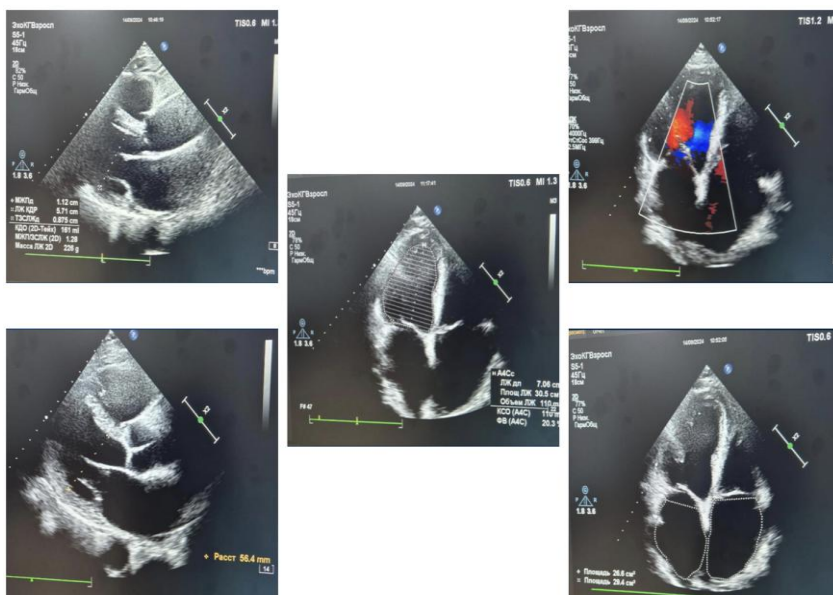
Cardiac ultrasound on the 10th day of hospitalization. The study was conducted against the backgrounds of atrial fibrillation. Dilation of both atria is observed, with a decrease in dynamics. Diffuse hypokinesia of all walls of the LV and RV. The global systolic function of the left ventricle and EF is significantly reduced to 36%, with improvement in dynamics. Mitral and tricuspid valve insufficiency of grade 1. Diastolic dysfunction of the left ventricle of type 1.
